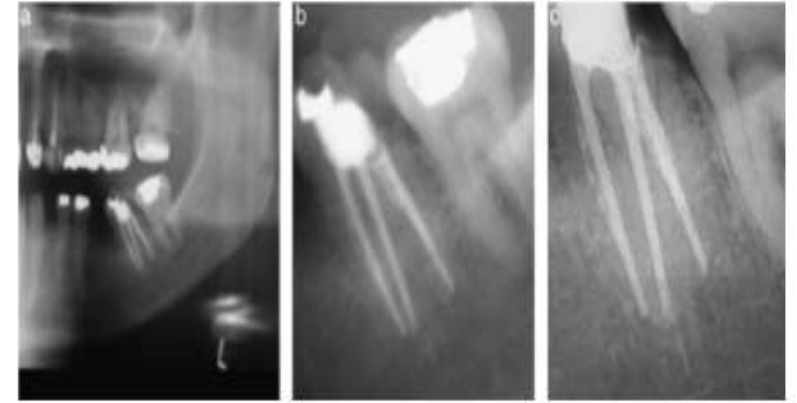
(A) Panoramic radiograph of completed root canal therapy of the lower left second molar. Radiograph shows proximity to the inferior alveolar canal; (B) isolated image of the second molar shows radiopaque material beyond the mesial root and root shapes that have transported the original canal positions; (C) magnification identifies an overinstrumented root canal providing a pathway for injury by instruments and/or scaler. Patient experienced permanent paresthesia in the inferior alveolar distribution on the face.
